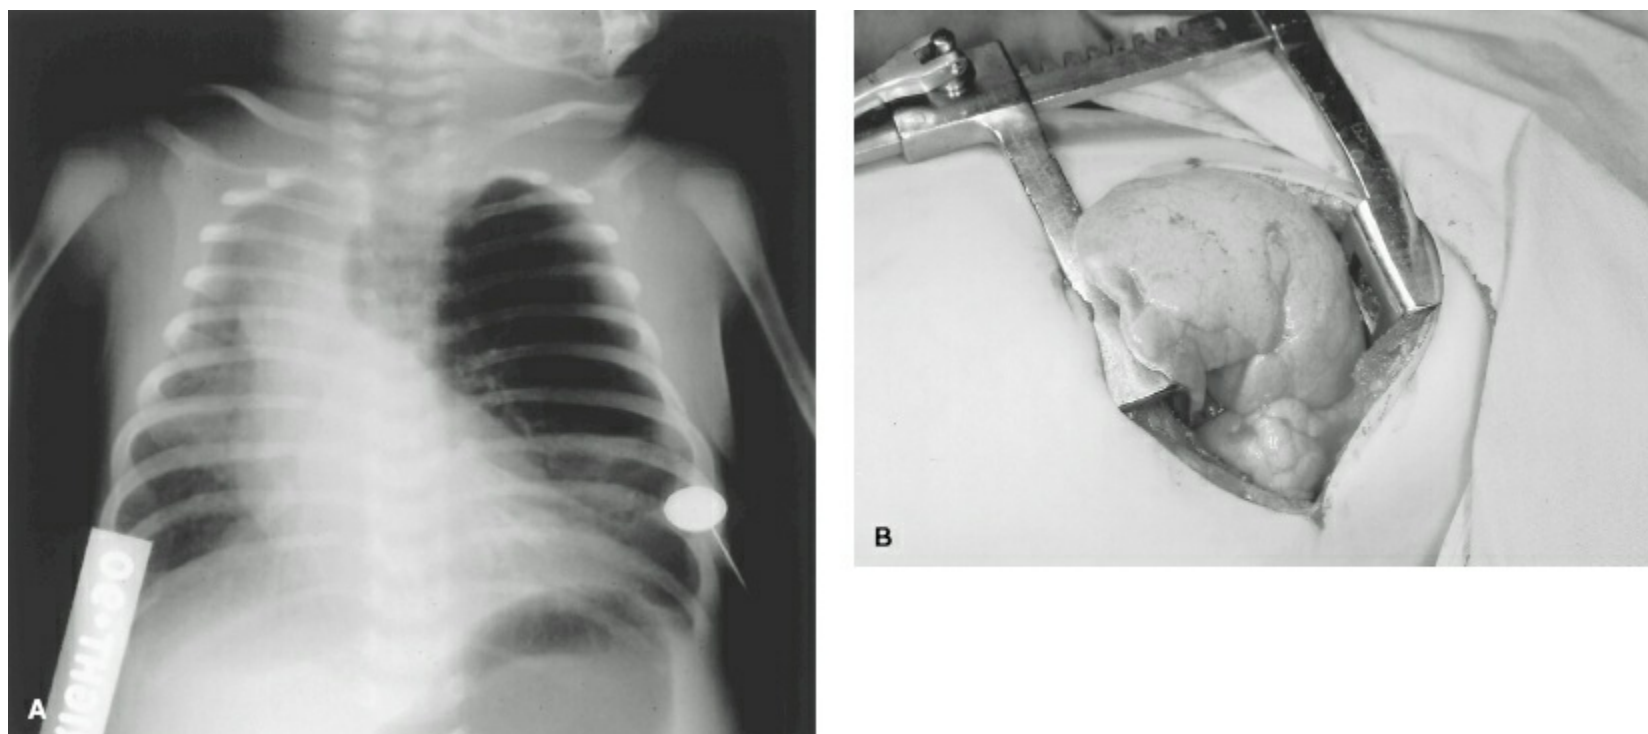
Congenital lobar overinflation. A: Chest radiograph demonstrating overinflation of the left upper lobe in an infant. Note the mediastinal shift. B: Operative photograph demonstrating an overexpanded left upper lobe decompressing through the incision.
